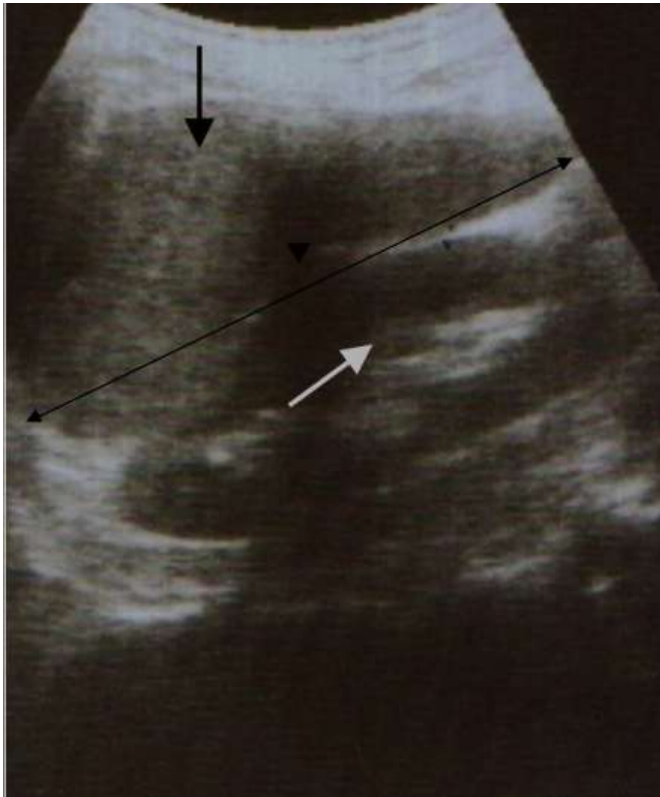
Sonogram showing the assessment of splenomegaly using the longitudinal dimension through the splenic hilum. Black arrow point to spleen, black arrow head point to splenic hilum, white arrow point to left kidney.
